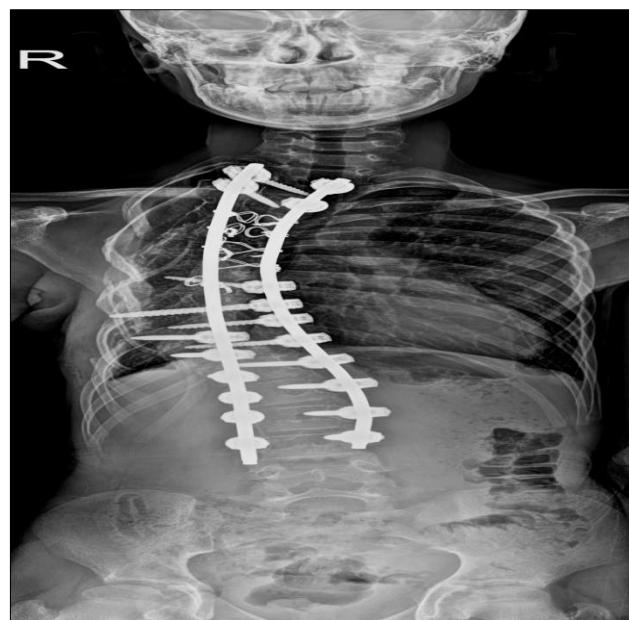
Plain radiograph showing post-operative status following scoliosis correction with spinal instrumentation and costoplasty.
